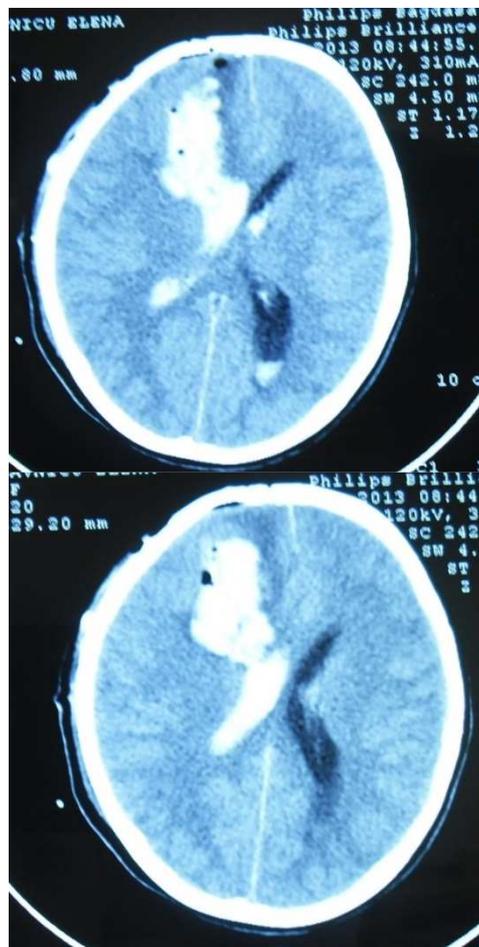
CT scan 24 hours postoperatively revealed a new blood clot that needed surgical intervention
